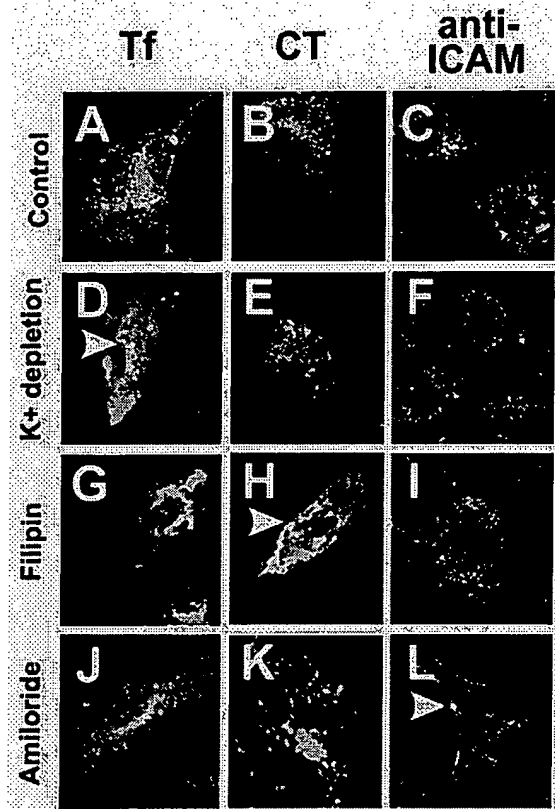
Anti-ICAM-1 conjugates are not internalized by clathrin or caveolae-mediated endocytosis. TNF- α -activated HUVEC were untreated (A-C), potassium-depleted (D-F), or treated for 30 minutes at 37°C with 1 μ M/ml filipin (G-I), or 3 mM amiloride (J-L). The cells were incubated in the presence or absence of inhibitors for 1 hour at 37°C with fluorescent transferrin (Tf: A,D,G,J), fluorescent cholera toxin (CT: B,E,H,K) or anti-ICAM-1 immunobeads (C,F,I,L), then fixed and counterstained to double-label surface-bound material (yellow, arrowheads). As shown, potassium depletion specifically inhibited transferrin uptake by clathrin-mediated endocytosis (D), filipin specifically inhibited caveolar uptake of cholera toxin (H) and amiloride specifically inhibited uptake of anti-ICAM-1 immunobeads (L).
